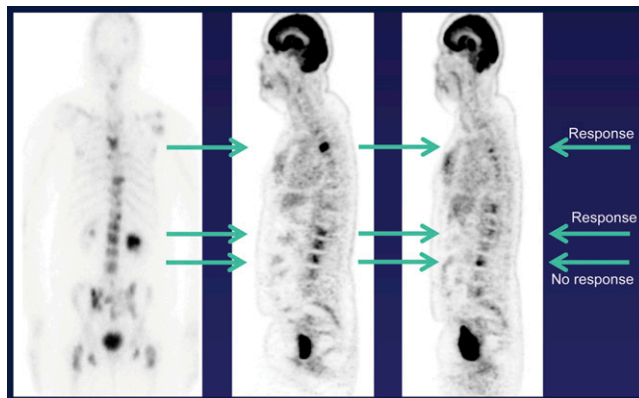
^{18}F -FDG PET/CT and ^{223}Ra therapy. Left: baseline bone scan. Middle: baseline ^{18}F -FDG PET image. Right: ^{18}F -FDG PET acquired after 2 injections of ^{223}Ra showed a significant decrease ($>25\%$ decrease in SUVmax) in tracer uptake intensity in multiple, though not all, bone metastases located in the thoracic and lumbar spine, indicating a partial metabolic treatment response in several tumor foci early in ^{223}Ra therapy.
